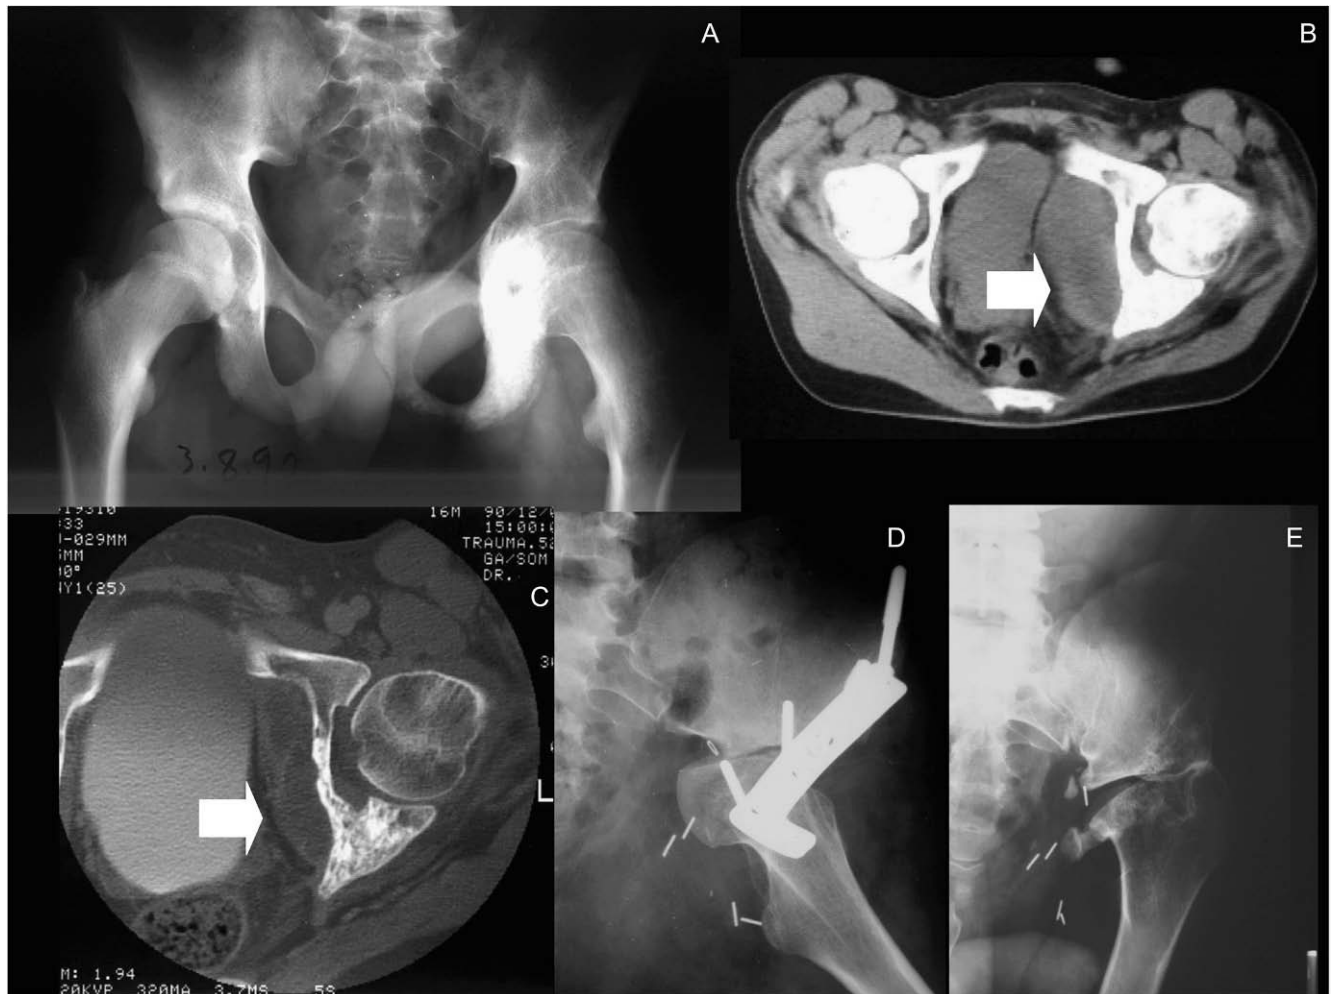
A) Radiograph of the patient described in Case 1 showing increased bone density in areas ii and iii of the left hemipelvis and osteolytic lesions in the ischial portion of the bone. B) Computerized tomography (CT) of the patient described in Case 1 showing bony involvement caused by an Ewing sarcoma as well as an intrapelvic soft tissue mass created by the tumor (arrow). The study was performed prior to administration of chemotherapy. C) Post-chemotherapy CT. D) Left pelvifemoral arthrodesis following tumor resection in the patient described in Case 1. E) Current follow-up radiograph of the same patient. He presents with a well tolerated iliofemoral pseudoarthrosis.
